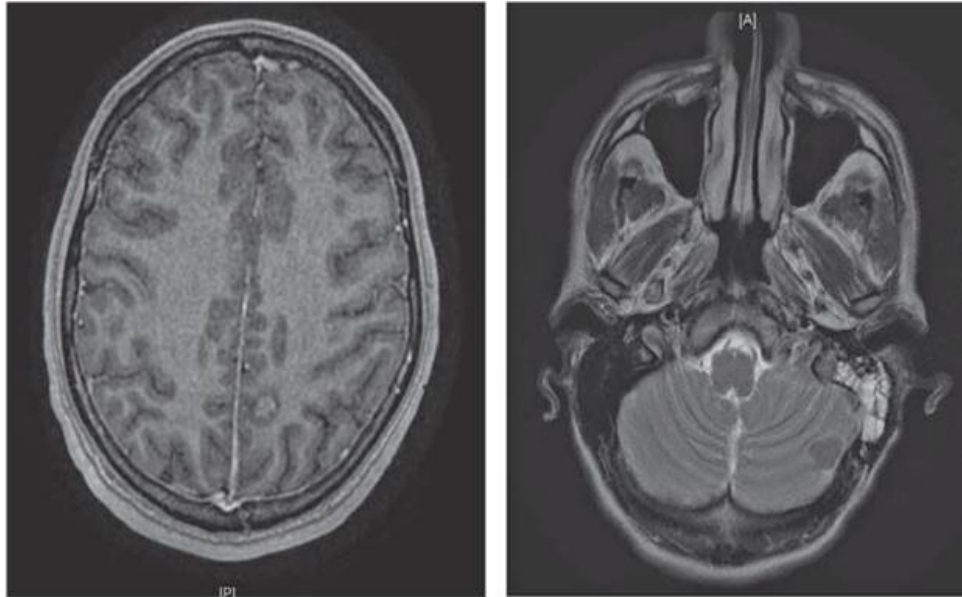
Magnetic resonance imaging showing (a) a cerebral tuberculoma in the left frontoparietal region and (b) a left cerebellar tuberculoma.
